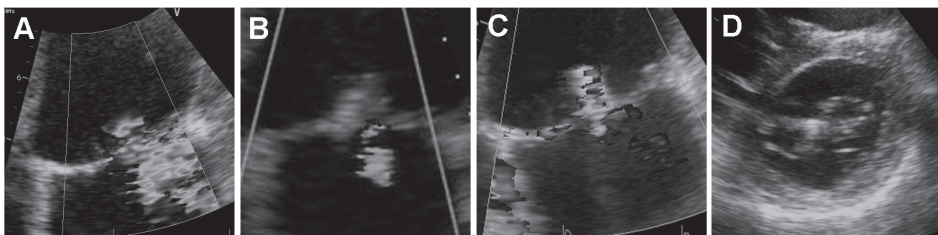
Transthoracic echocardiograms from a patient undergoing percutaneous edge-to-edge repair with the use of a MitraClip device. Severe MR is present at baseline (panel A). After placement of the MitraClip device there is immediate reduction in MR (panel B) with continued success on 2-year follow-up (panel C). Double barrel mitral orifice is seen on the short axis view (panel D).
